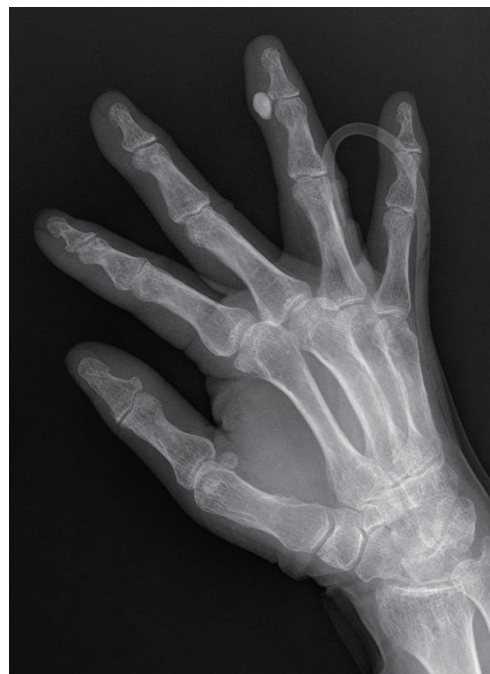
The initial radiographs showed an ovoid calcification on the radial collateral ligament of the distal interphalangeal joint of the left fourth finger.
